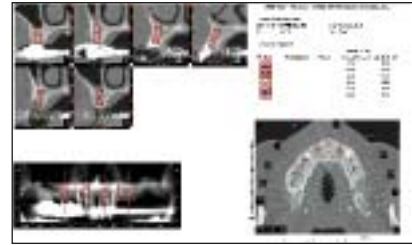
CT preview showing location, position and size of implants
